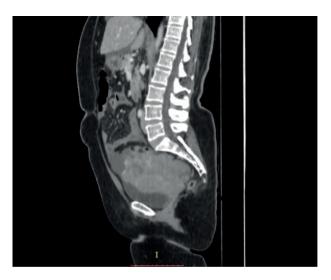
Sagittal view of computed tomography scan of abdomen post contrast administration, showing a heterogeneously enhancin pelvic mass extending into lower abdomen, likely of adnexal origin. There is mild right hydroureteronephrosis and moderate ascites.
